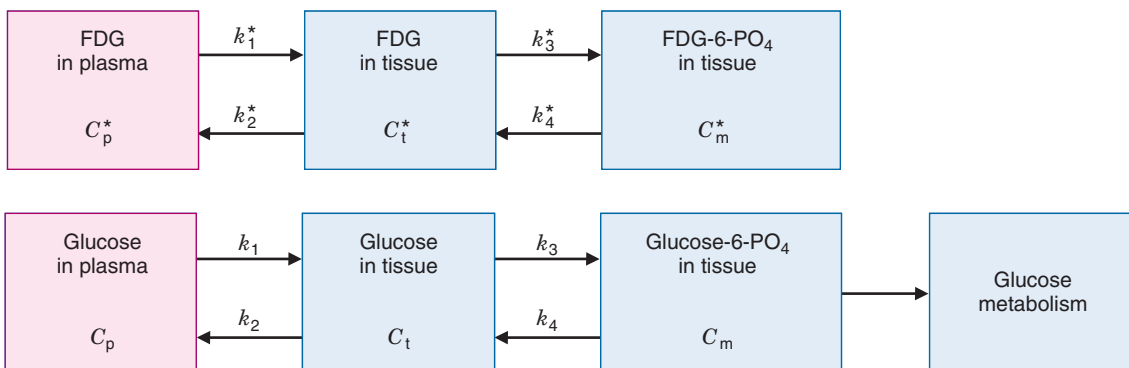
Transport and metabolic pathways for glucose and 2-deoxy-2-[ $^{18}\text{F}$ ]fluoro-D-glucose (FDG). Physically, the “free” compartment represents a combination of the interstitial space and the cytosol (the fluid component inside the cell, excluding the nucleus) in both of which unphosphorylated glucose and FDG are uniformly distributed. The red crosses indicate that FDG-6- $\text{PO}_4$ , unlike glucose-6- $\text{PO}_4$ , is not further metabolized.
